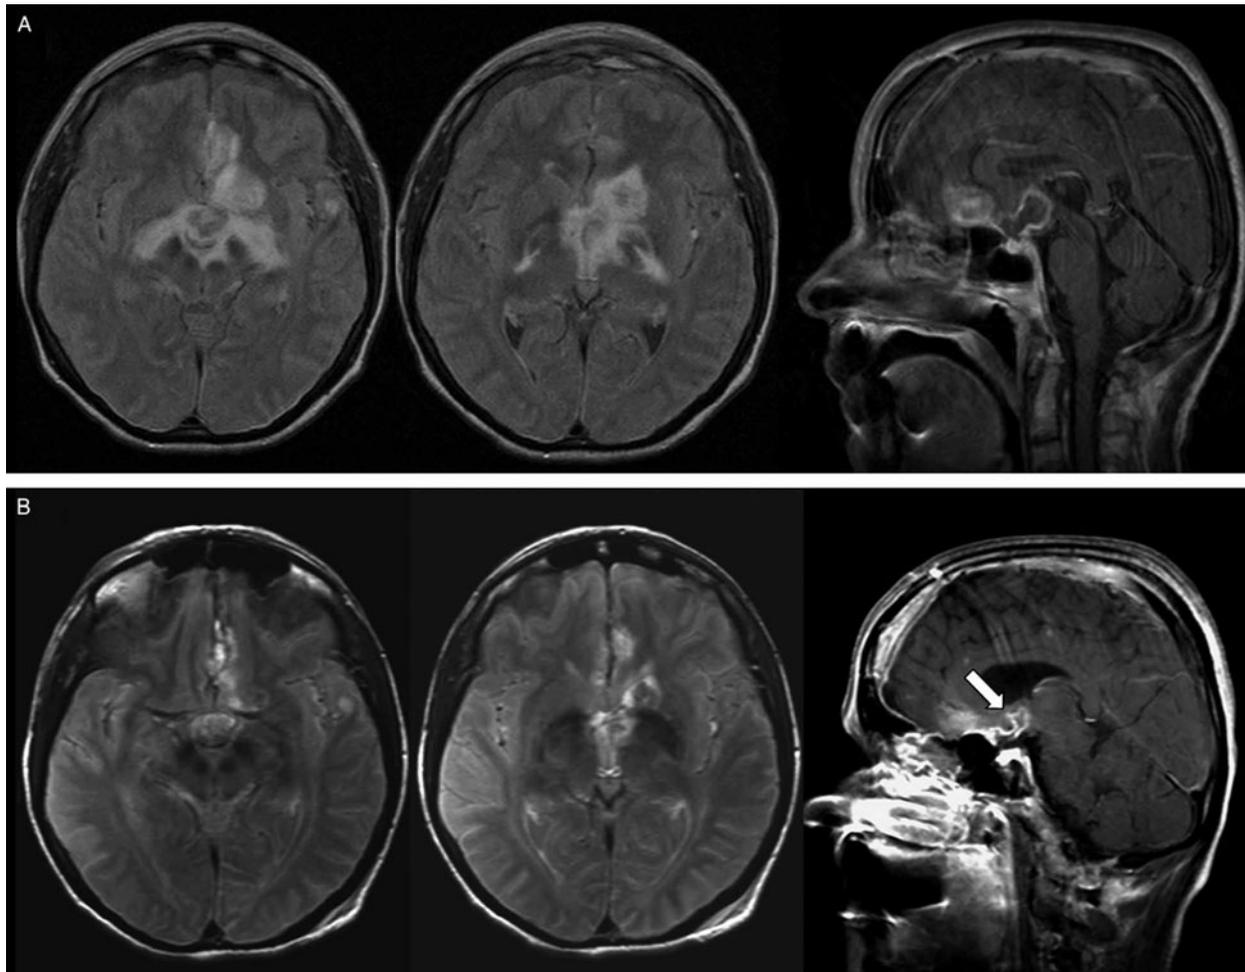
Postoperative evolution of MRI changes. MRI performed on 16 March 2007 (A, upper panels) at the nadir of the patient's clinical condition showed marked extension of the signal abnormalities with mass effect involving the basal ganglia bilaterally (especially on the left) and the left orbitofrontal gyrus. A rim of contrast enhancement bordered the area of the lesion. Follow-up MRI performed on 11 April 2007 around 3½ weeks after adaption of therapy according to the diagnosis of EBV encephalitis (B, lower panels) demonstrated a significant reduction of signal abnormalities with parts of the lesion appearing necrotic (*arrowhead*). This was paralleled by a significant improvement of the patient's neuropsychiatric symptoms.
